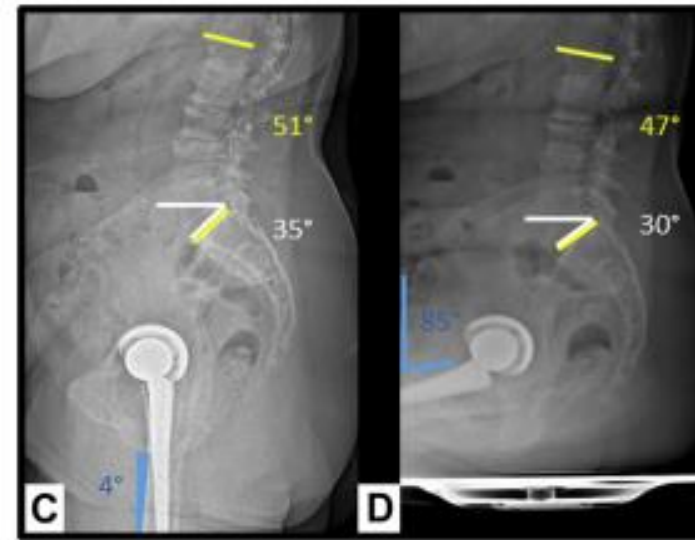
(A) Standing lateral and (B) sitting lateral 2-dimensional radiographs of the spine and pelvis of Patient 1, a 60-year-old man without spine arthrosis. Patient 1 stands and sits with 43° and 6° of sacral slope, respectively. Therefore the patient's pelvis has more posterior pelvic tilt (rotated backward 37°) in sitting position. In contrast, (C) standing lateral and (D) sitting lateral 2-dimensional radiographs of the spine and pelvis of Patient 2, a 56-year-old woman with spine disease, show little change in sacral slope angles from 35° in (C) standing to 30° sacral slope in (D) sitting. Patient 1 experienced 43° of spine flexion (59°–16°) and 54° of hip flexion (95°–4° + 6°–43°). Patient 2 experienced less of spine flexion (4°) compared to Patient 1 and therefore more hip flexion (76°). Yellow lines and numbers show the lumbar lordosis angles, white lines and numbers show the sacral slope angles, and blue lines and numbers show the proximal femoral angles.
